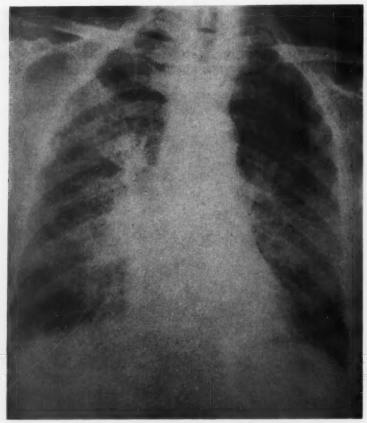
Case 13. Posteroanterior chest x-ray, 10/7/53. X-ray report: "Both hemi-diaphragms are flattened . . . the right costo-phrenic angle is slightly obscured due to a very small pleural effusion . . . numerous mottled densities in both lung fields, which could be due to tuberculosis, fungus infection or widespread carcinomatosis . . . heart slightly enlarged in its transverse diameter, with some flattening of the left border indicative of myocardial damage." Thoracentesis of the right hemithorax immediately following this x-ray examination yielded 800 ml. of pleural fluid.
